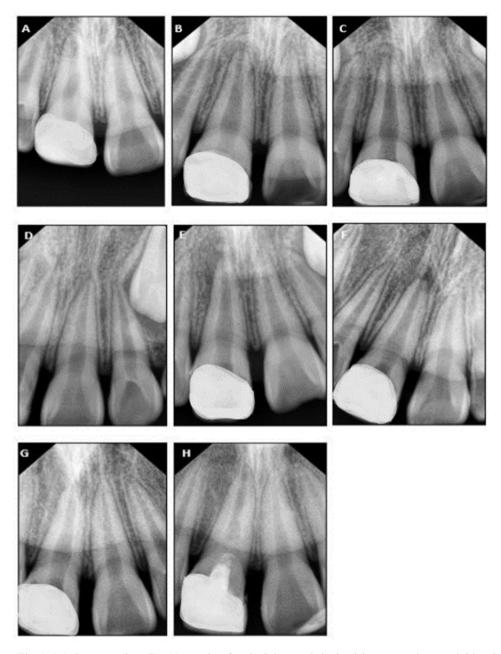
(A): Pre-operative, (B): 11 months after the injury and single visit regeneration was initiated, (C): Follow-up radiographs 5 months, (D): the periapical radiolucency has resolved 9 months after regenerative endodontic, (E): 13 months (F): 21 months, (G): 30 months, apex closure was observed after regenerative endodontic (H): 36 months
